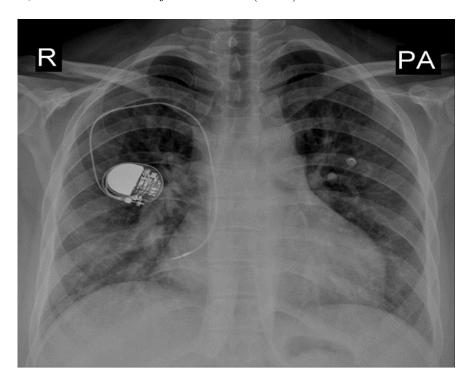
Chest X-ray PA view revealed non homogenous opacity in both lungs.
